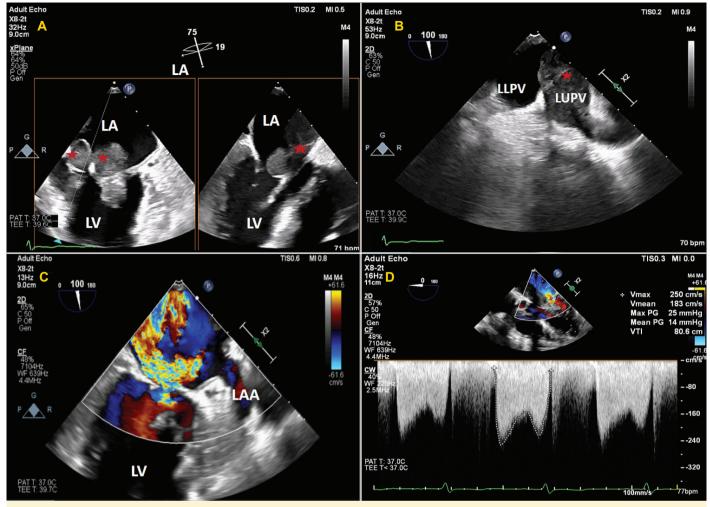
Transesophageal echocardiography. (A-B): X-plane imaging and a 100° view demonstrate multilobed heterogeneous masses that extend from the interatrial septum to the anterolateral commissure, cover the anterior and posterior mitral leaflets, and fill the entire left upper pulmonary vein. (C-D): Color and continuous wave Doppler imaging demonstrate both moderate to severe mitral regurgitation and stenosis, with increased mean and peak transmitral gradients (14 mmHg and 25 mmHg, respectively).
